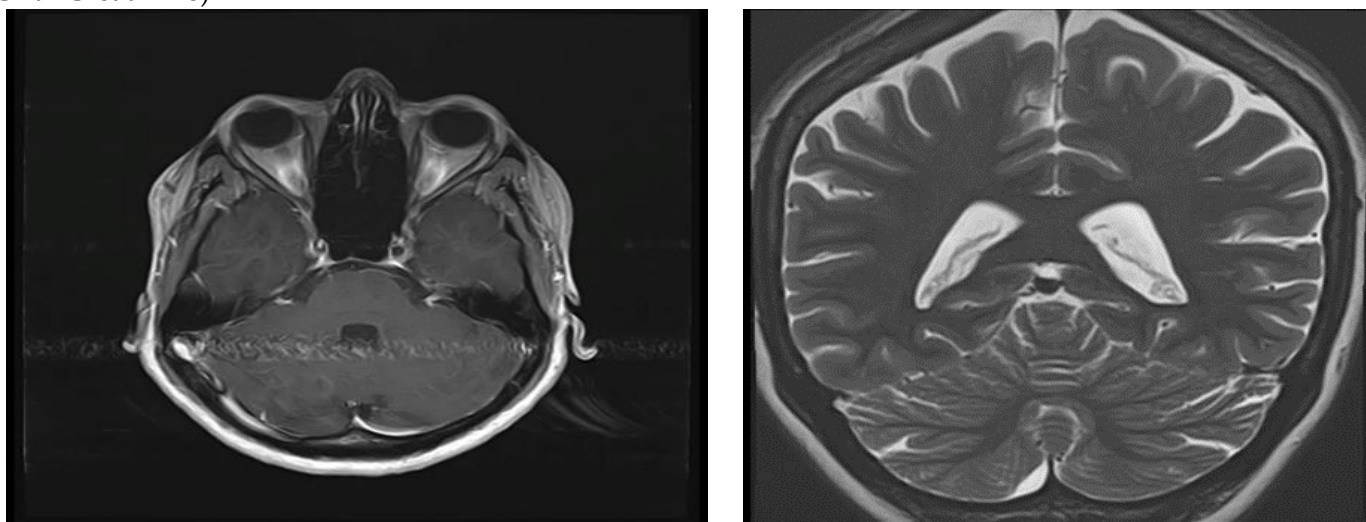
MRI scans of the patient presenting with lamotrigine overdose
